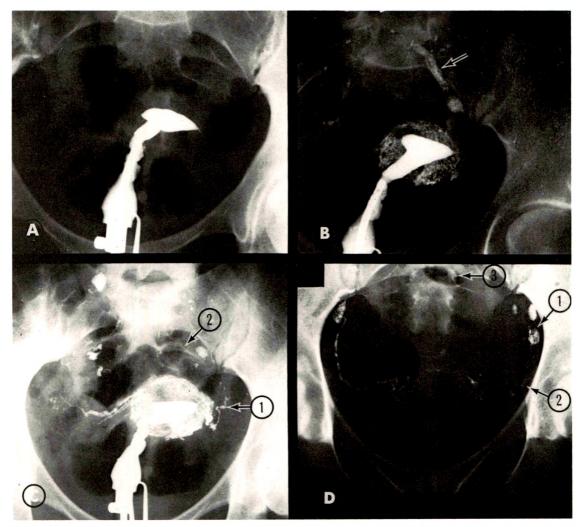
Sequential studies from the hysterosalpingography with ethiodol. (A) The uterine cavity is normal. Only the proximal portion of the left tube is visualized. (B) The intrauterine lymphatics are seen in lamellar fashion with opacification of some efferent pedicles draining the uterus. There is minimal and transient opacification of the left internal iliac vein (arrow). (C) The major efferent lymphatic pedicles demonstrated are (1) external iliac and (2) sacral pedicles. (D) The 24 hour roentgenogram shows retention of contrast material in the (1) external iliac, (2) hypogastric and (3) promontory lymph nodes.
